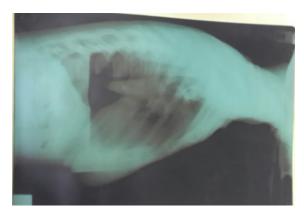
Lateral view of Chest X-ray after drainage.
